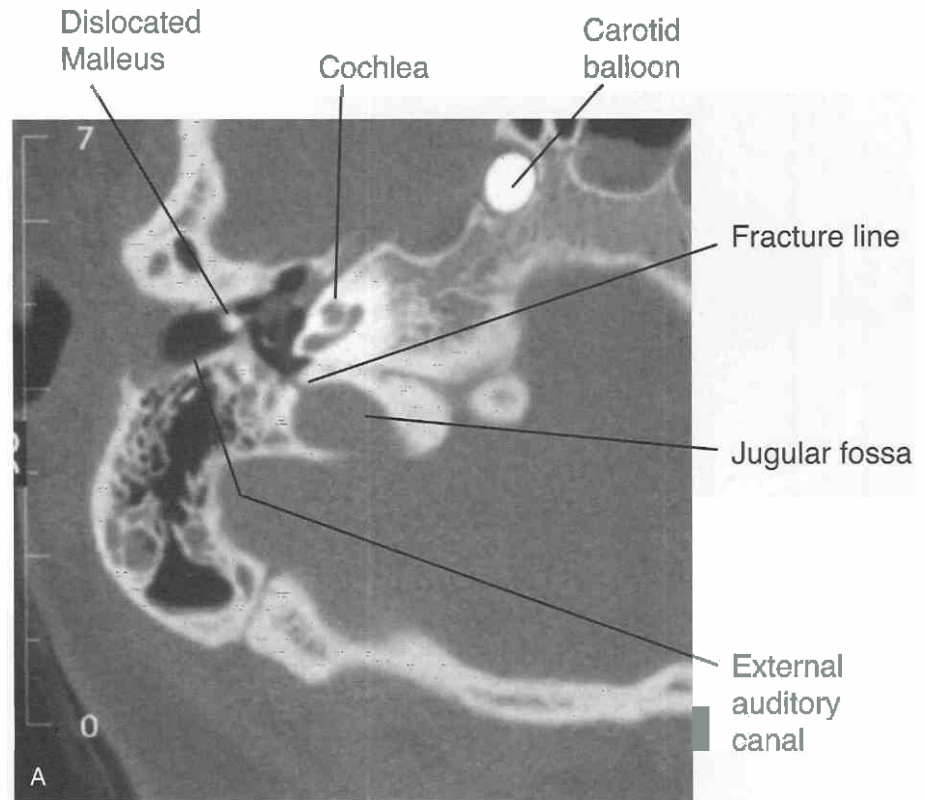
Transverse fracture. *A*, Axial CT image through the cochlea demonstrates dislocation of the ossicles (head of the malleus) into the external auditory canal and tympanic membrane. The normal position of the long process of the malleus is not seen. A linear fracture crosses obliquely into the jugular fossa. *B*, CT section through the epitympanic space demonstrates an absence of the head of the malleus and the body of the incus; they have been dislocated inferiorly. An oblique transverse fracture runs posterior to the posterior semicircular canal. A fracture of the geniculate ganglion canal is too wide to be normal. The mastoid air cells are partially opacified. A balloon is present in the carotid canal as a result of a carotid-cavernous fistula.
